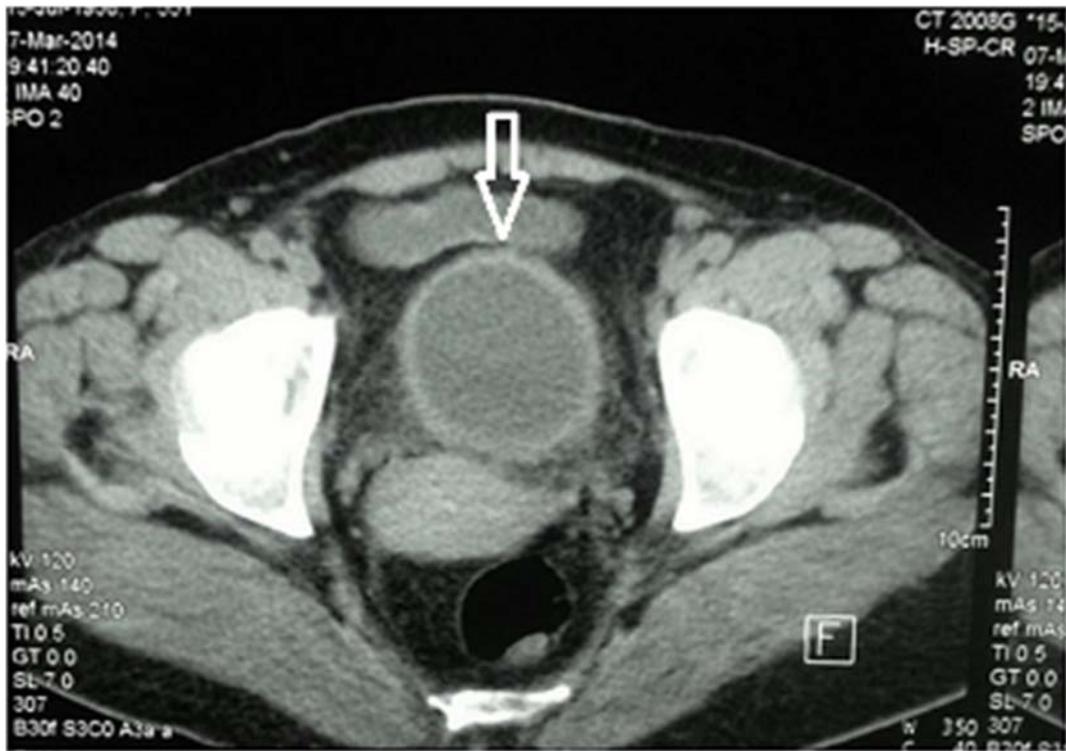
Follow-up computed tomography (CT) scan showing marked reduction in bladder wall thickness and residual fat stranding (arrow)
